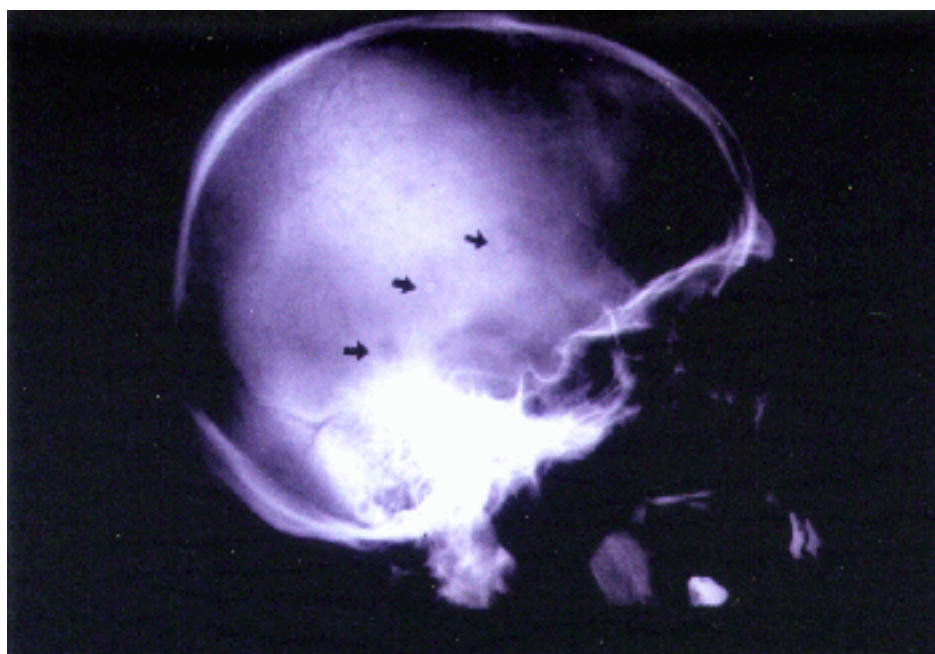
Radiograph of a skull showing multiple "punched-out" osteolytic lesions (Patient 4).
